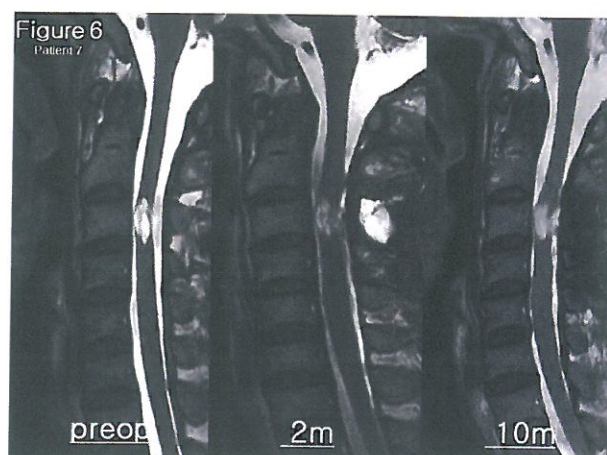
In Patient 7, cavity size was decreased and dorsal side of spinal cord around the cavity was thickened in T2 weighted image of the follow-up MRI.
